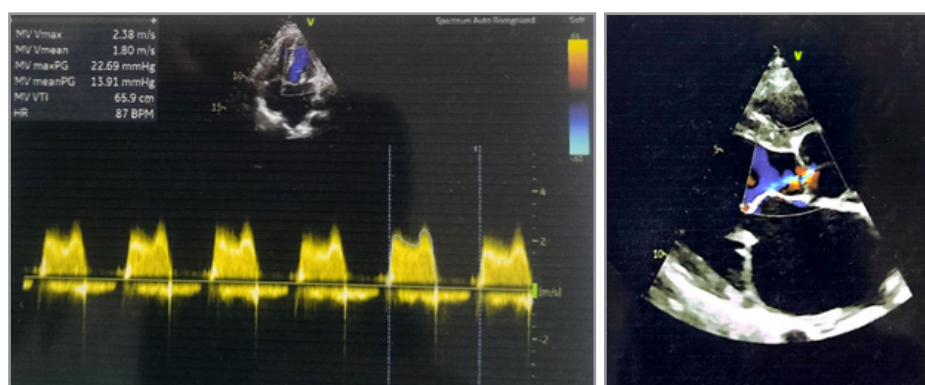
Photograph of Echocardiography Showing Diastolic Doming of Anterior Leaflet, Thickening of Valve Leaflets, Restricted Opening of the Valve & Dilatation of the Left Atrium
